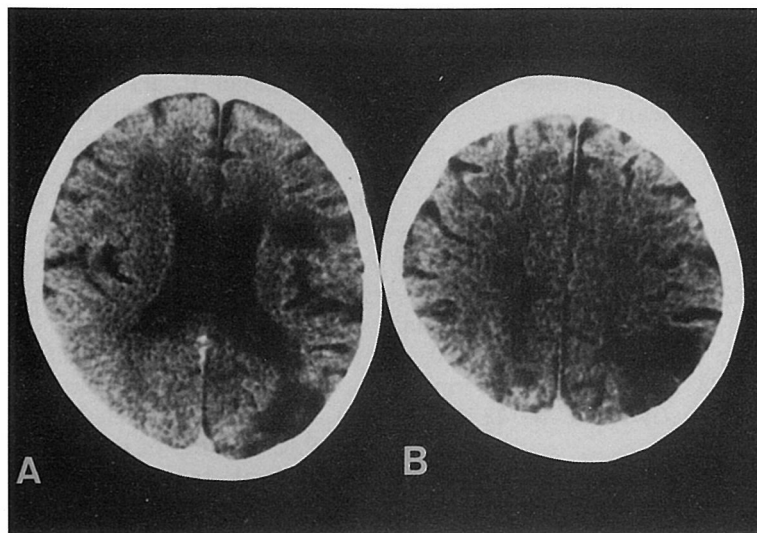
Computerized tomography (CT) scans in case 3. Plain CT (A and B) shows multiple infarcts in the right frontal, parietooccipital and the left parietal lobe.
